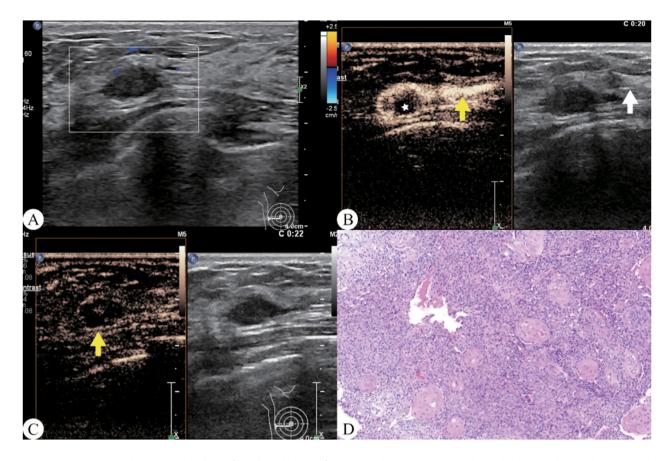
A patient presented with serous discharge from the right breast for one month. A Breast ultrasound revealed a hypoechoic nodule at 9 o'clock of the right breast, 30 mm from the nipple. The relationship between this nodule and the duct and discharge was unclear. B Ultrasound galactography clearly showed a continuous duct communicating with the nodule (yellow arrow), with the contrast agent surrounding half of the nodule (star). However, visualizing the discharge duct in two-dimensional mode remained challenging (white arrow). C CEUS showed the hypoechoic nodule exhibiting heterogeneous hypo-enhancement (arrow). D Pathology identified the lesion as an intraductal papilloma
